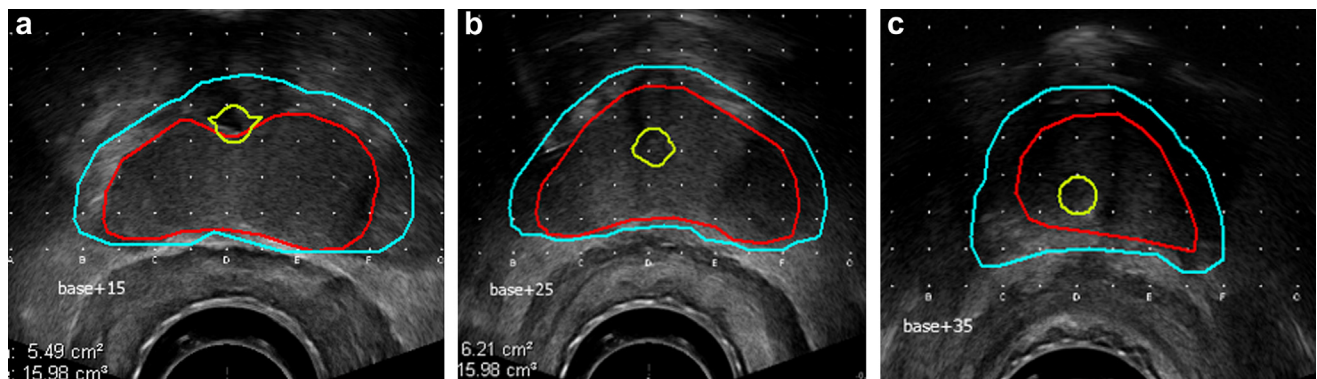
Three images from TRUS mapping showing (a) the base + 15 mm, (b) base + 25 mm, and (c) base + 35 mm (apex). TRUS = transrectal ultrasound.
